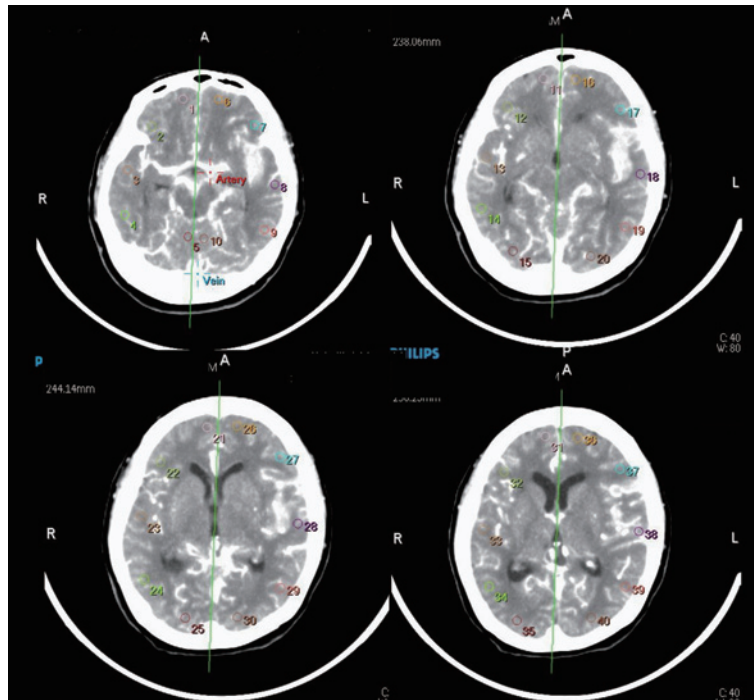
Regional CT images of case 20. The standardized region of interest (ROIs) strategy is demonstrated. Circular ROIs were delineated in the peripheral (cortical) flow territories of the anterior cerebral artery, middle cerebral artery, and cerebellum, resulting in 40 ROIs per patient.
